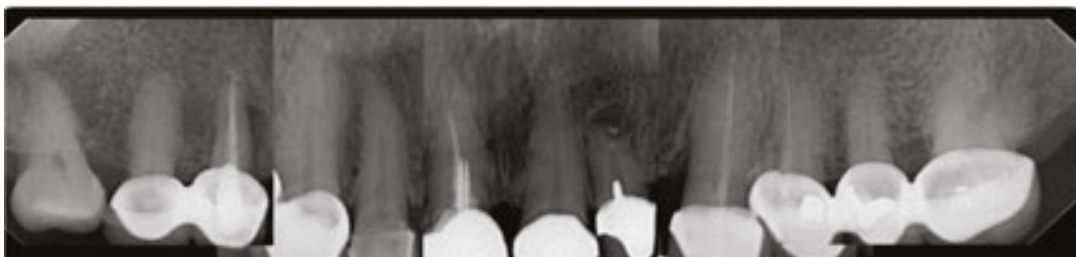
The radiographs show some failing teeth but the bone support is basically good.
